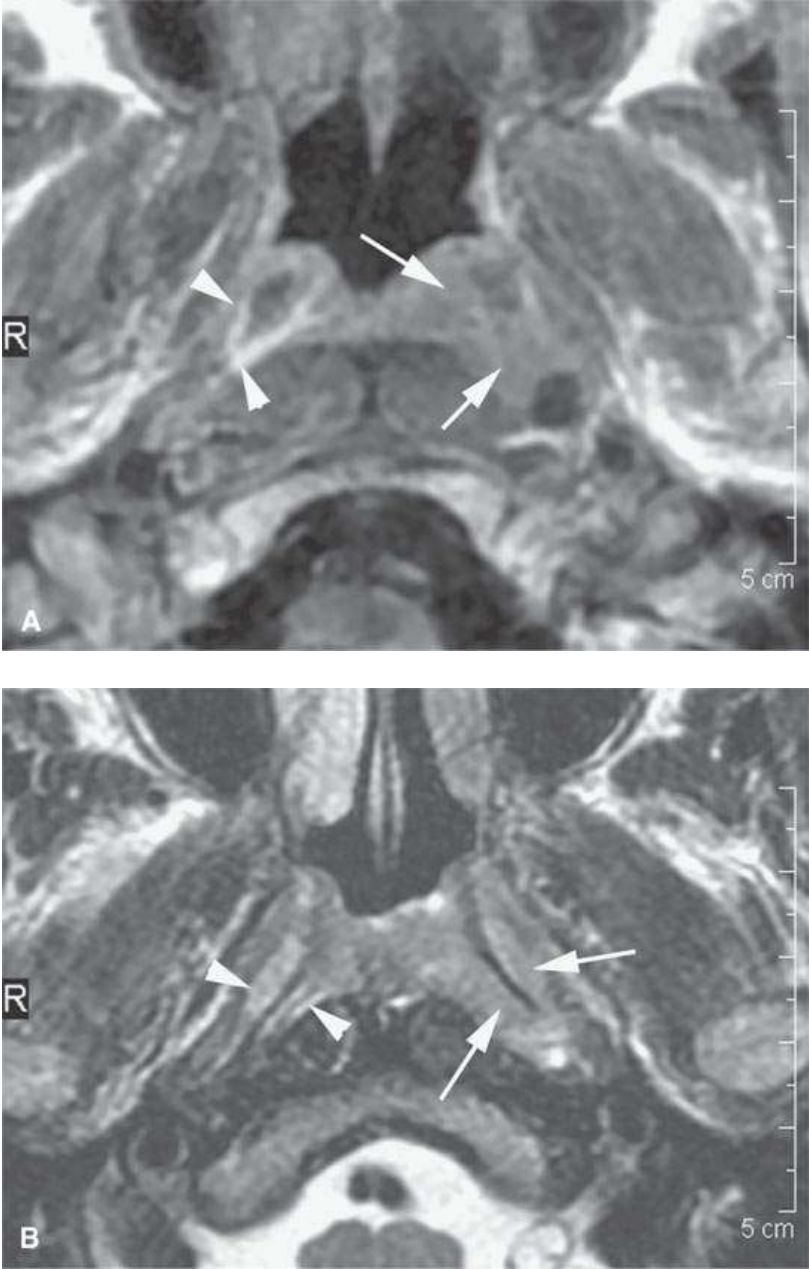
A patient with submucosal nasopharyngeal cancer not visible to the endoscopist, the patient presenting with chronic middle ear disease. The entirely submucosal squamous cell carcinoma invades the deep tissue planes (*arrows*) on the left compared to the normal side (*arrowheads*) on the right on both the contrast-enhanced T1-weighted image (aA) and the T2-weighted image (bB).
